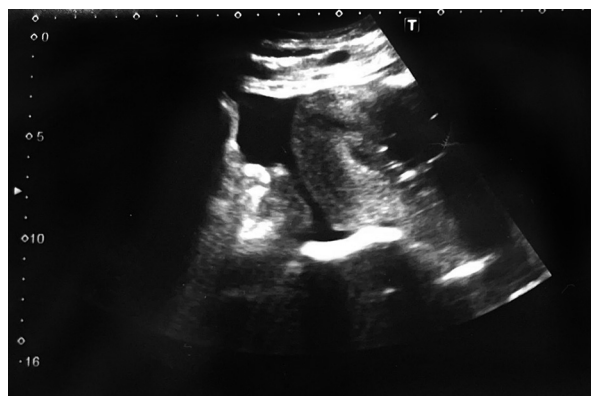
Postoperative ultrasound image of minimal free intraperitoneal fluid collection
